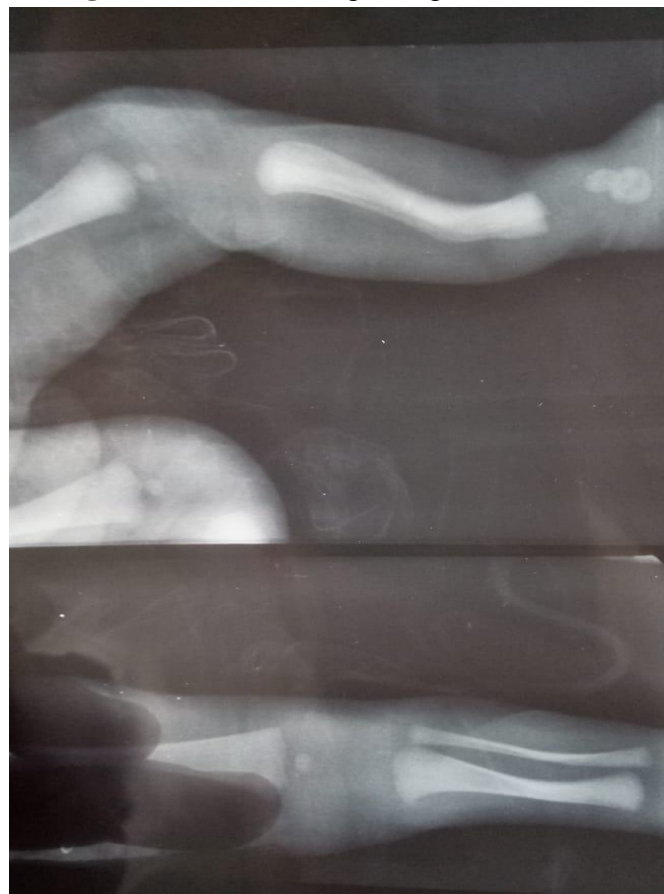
X-ray findings showing posterior bowing of both tibia as well as fibula along with an increase in cortical density and narrow sclerotic medulla.
